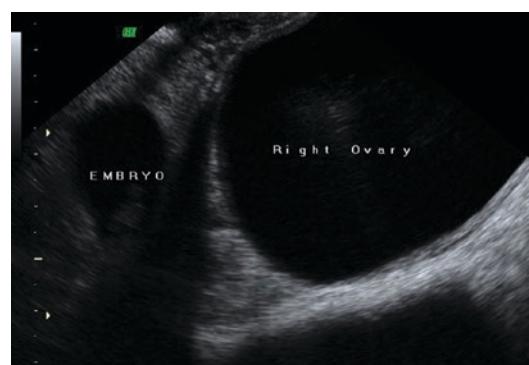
Ultrasonographic image showing a right ovarian cyst in pregnancy at 6 week and 5 days of pregnancy
